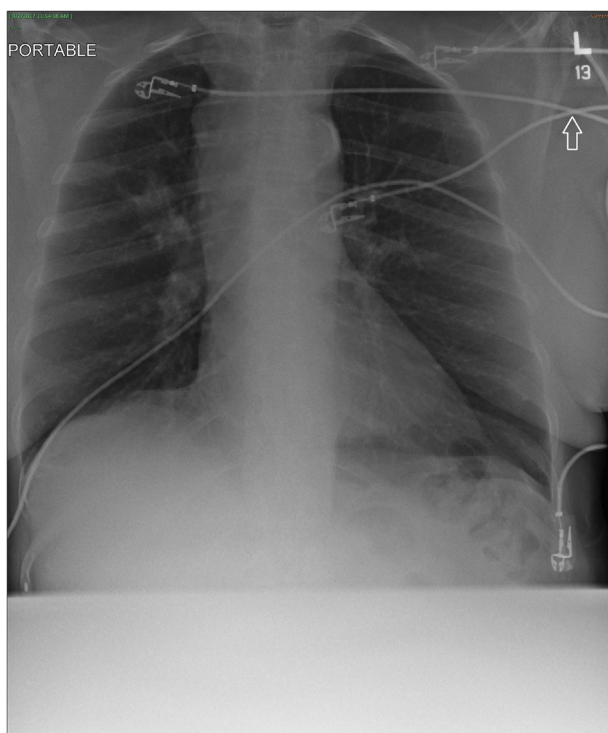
Portable Chest X-ray on presentation.
